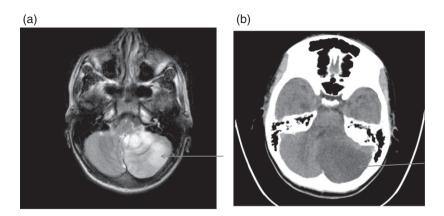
Massive cerebellar infarction. Ten-year-old male presented with acute onset of headache and dizziness. He was ataxic and had mild left sided weakness. Imaging on admission showed a large left cerebellar infarct. He became drowsy and developed bradycardia over the next 24 hours. Computed tomography scan 24 hours later showed swelling of left cerebellar hemisphere and brainstem distortion due to the large left cerebellar infarct. He went on have emergency posterior fossa decompression. This case highlights the need for identifying and treating raised intracranial pressure in patients with large cerebellar infarcts.
